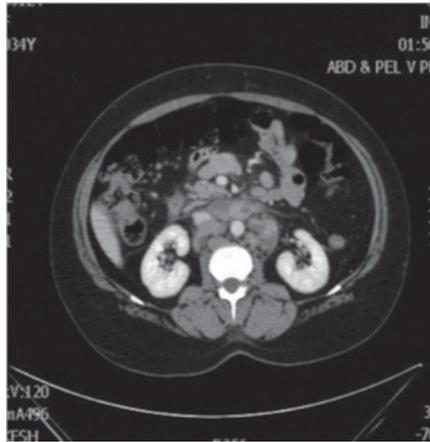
Axial CT Scan Showing Significant Regression of the Multiple Mesenteric and Retroperitoneal Enlarged Lymph Nodes
